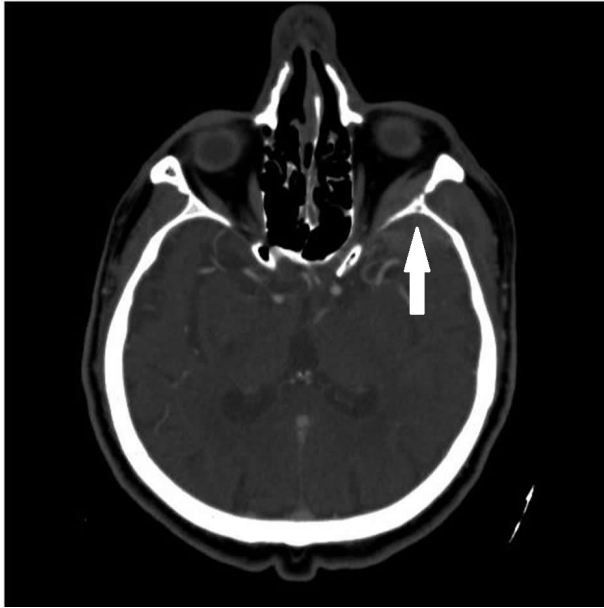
Brain CT; Sphenoid wing metastasis of prostate carcinoma (white arrow)
